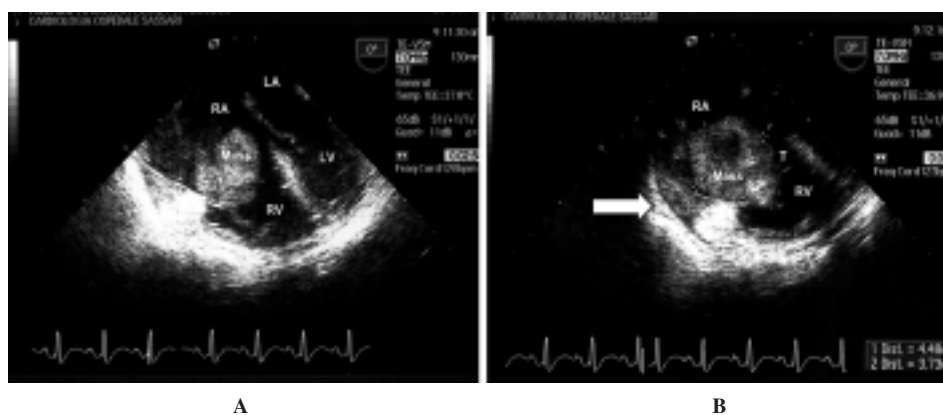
Transesophageal echocardiogram showing the inhomogeneity of the voluminous neoplastic mass (A) and the remarkable thickening, due to neoplastic infiltration, of the anterolateral wall of the right atrium (RA) and of the tricuspid annulus (T) (B, white arrow). LA = left atrium; LV = left ventricle; RV = right ventricle.
